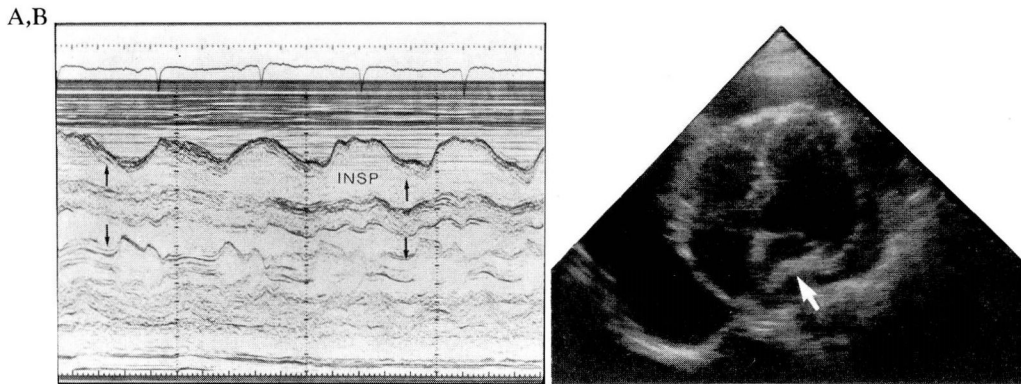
M-mode echocardiographic signs of cardiac tamponade are displayed. Arrows are located in the right ventricle and the left ventricular outflow tract. Each arrow is the same size. With inspiration (INSP) right ventricular filling is increased at the expense of left ventricular filling. Notice that when the right ventricle is less well filled the left ventricular outflow tract is larger. This is the M-mode echocardiographic sign of pulsus paradoxus. FIGURE 3B. Apical four-chamber two-dimensional echocardiogram demonstrates left atrial collapse (arrow), which can be an early sign of cardiac tamponade.
